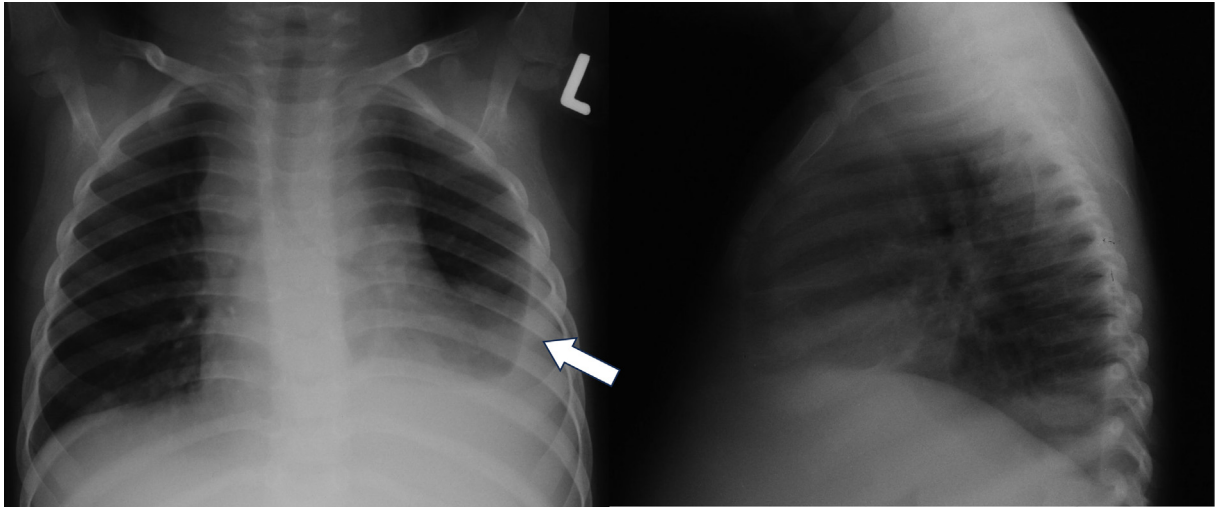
Frontal and lateral chest radiographs of an 18-month-old well-nourished HIV-negative infant with confirmed TB demonstrating left-sided pleural effusion (arrow).
